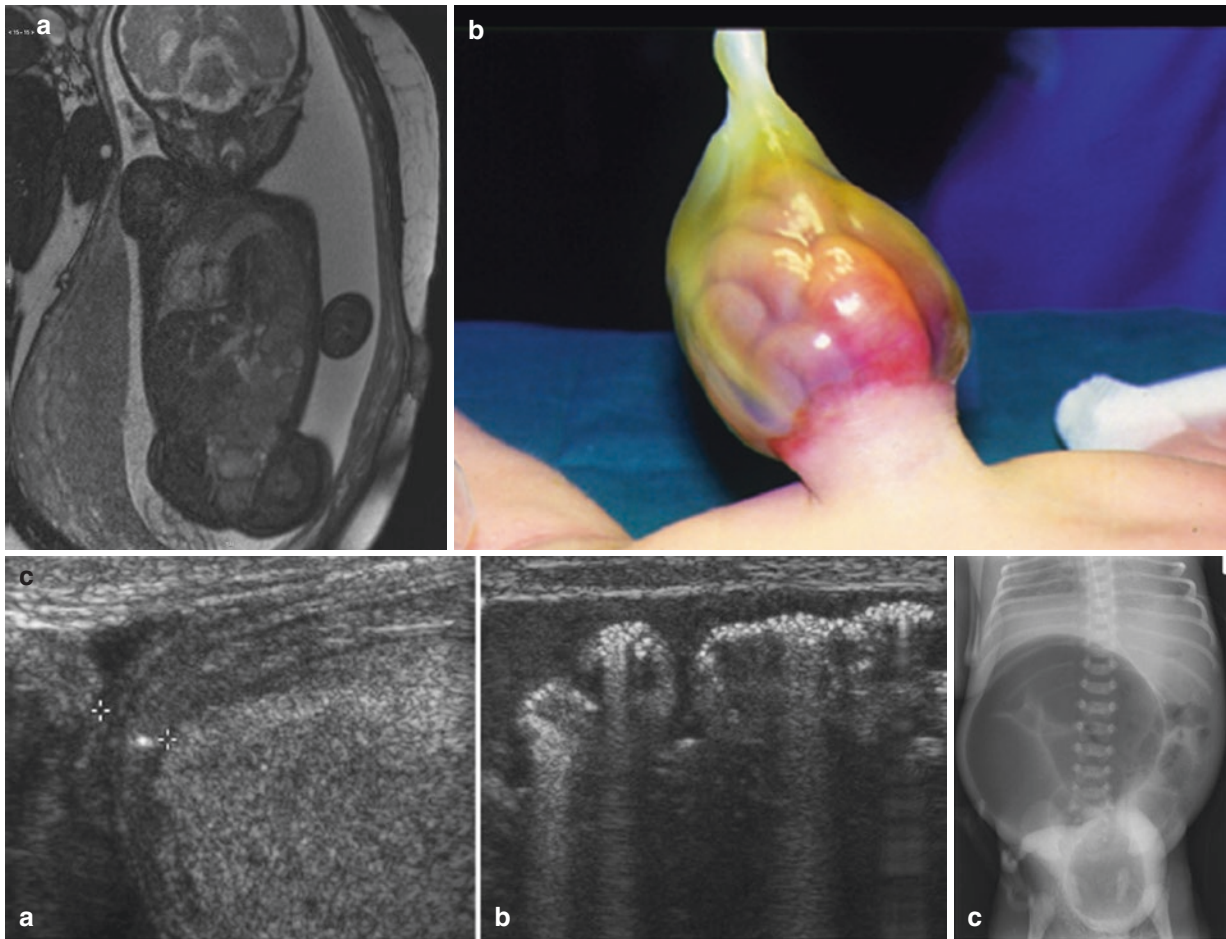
(a) Exomphalos antenatal MRI scan showing a protuberance on the abdominal wall suggestive of an exomphalos minor as the liver is not herniated yet. (b) Exomphalos/hernia into the cord. (c) Plain
